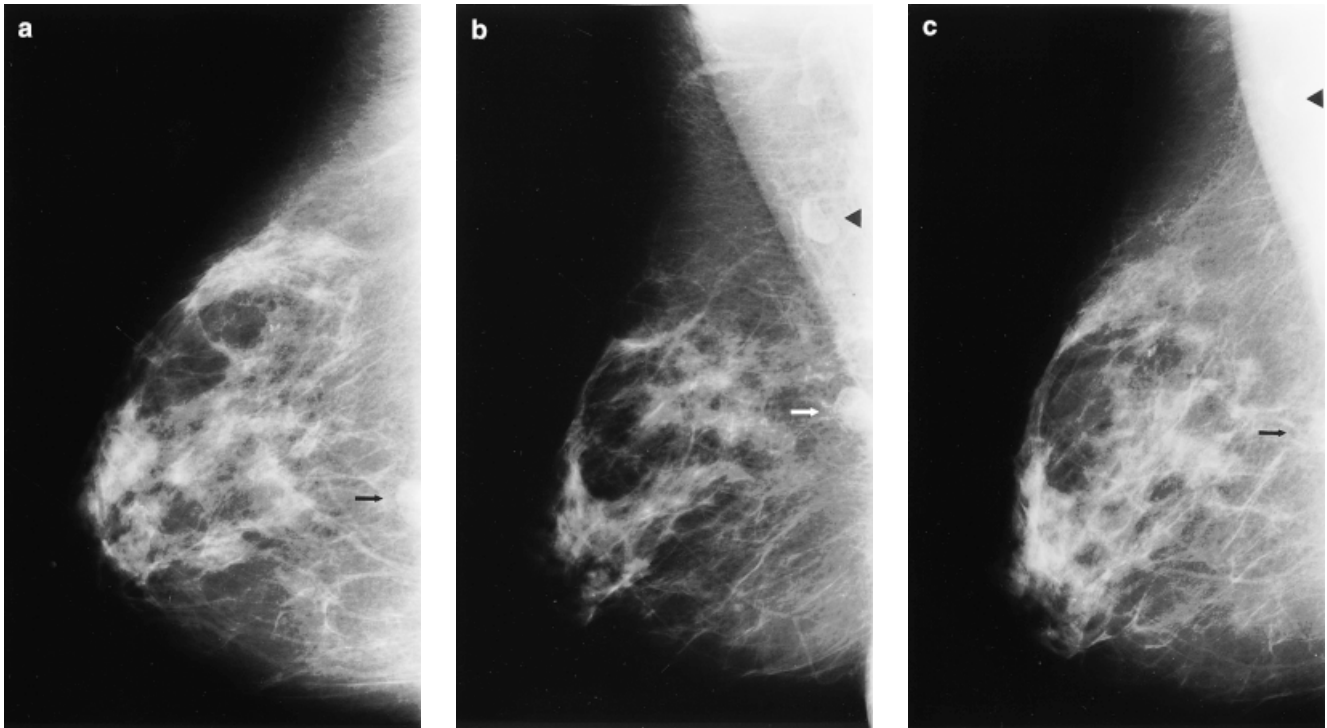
Cleopatra view. The Cleopatra view is anatomically equivalent to the mediolateral oblique view; however, the patient instead of the X-ray tube is obliqued. (a) Craniocaudal view shows a nodule (arrow) deep in the posterior central breast. (b) Mediolateral oblique view demonstrates the nodule (arrow) to be located in the deep posterior upper breast. An axillary lymph node overlies the inferior pectoralis muscle (arrowhead). (c) In the Cleopatra view the nodule (arrow) maintains an almost identical relationship to the axillary lymph node (arrowhead) and inferior margin of pectoralis muscle as in the mediolateral oblique view.
